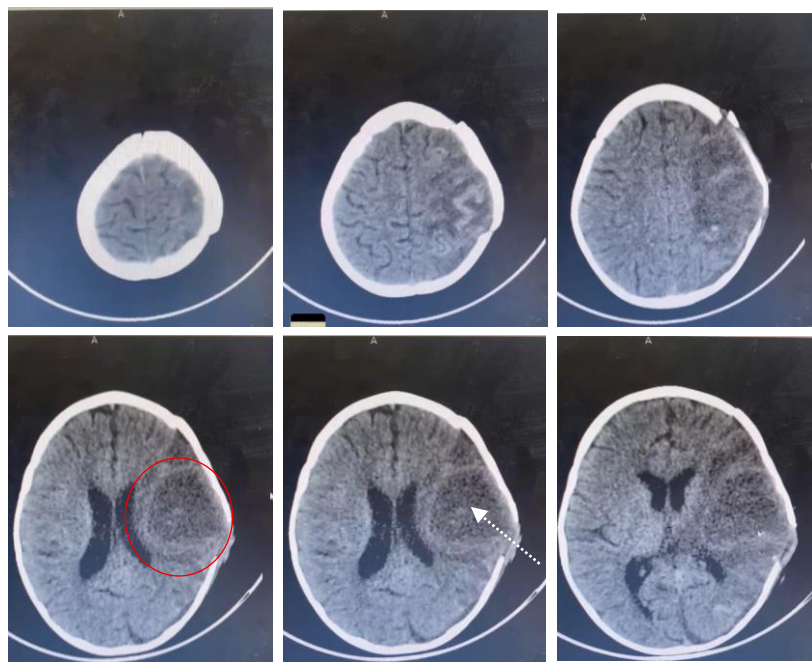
Non-contrast head CT findings on August 17, 2025.
